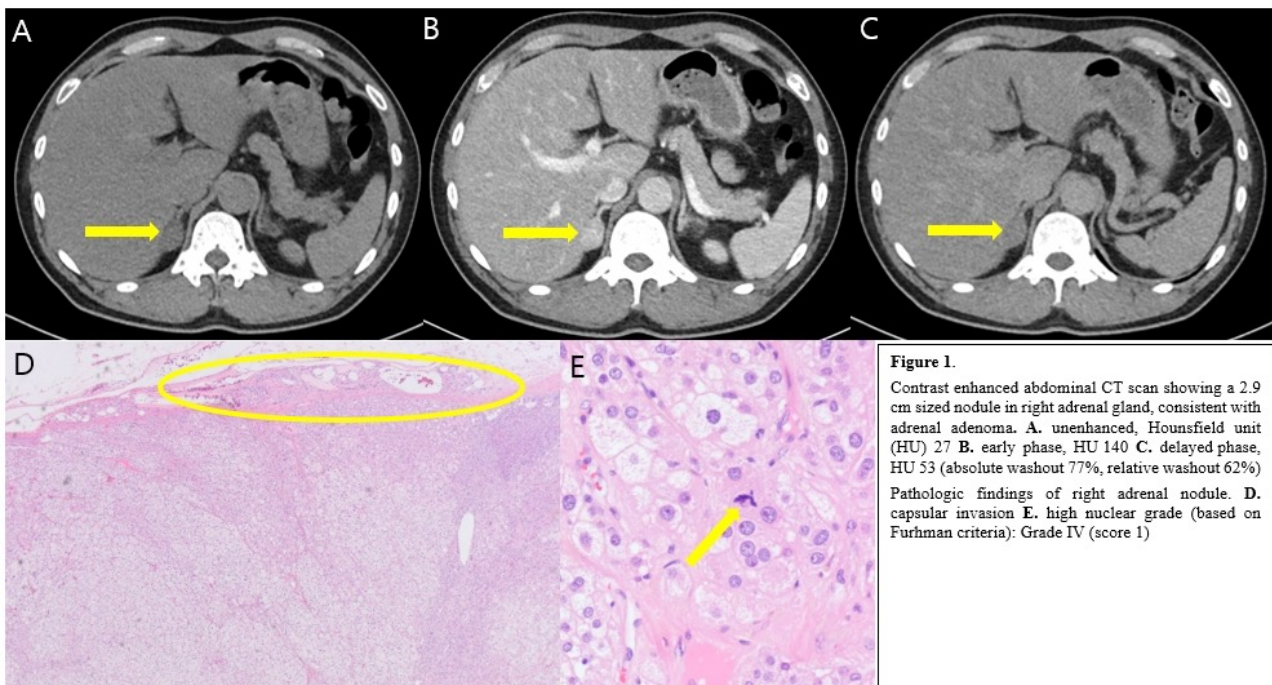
Contrast enhanced abdominal CT scan showing a 2.9 cm sized nodule in right adrenal gland, consistent with adrenal adenoma. A. unenhanced, Hounsfield unit (HU) 27 B. early phase, HU 140 C. delayed phase, HU 53 (absolute washout 77%, relative washout 62%) Pathologic findings of right adrenal nodule. D. capsular invasion E. high nuclear grade (based on Furhman criteria): Grade IV (score 1)
